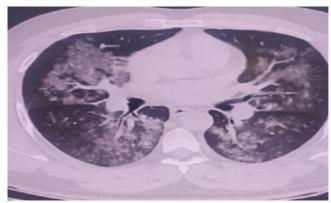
Postoperative thorax CT revealing consolidated alveolar ground glass densities in the bilateral parenchyma
